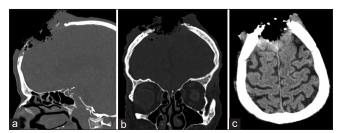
(a) Sagittal bone computed tomography scan. (b) Coronal bone computed tomography scan. (c) Axial computed tomography scan. It is evident the severe and profound destruction of the scalp layer done by the basal cell carcinoma
